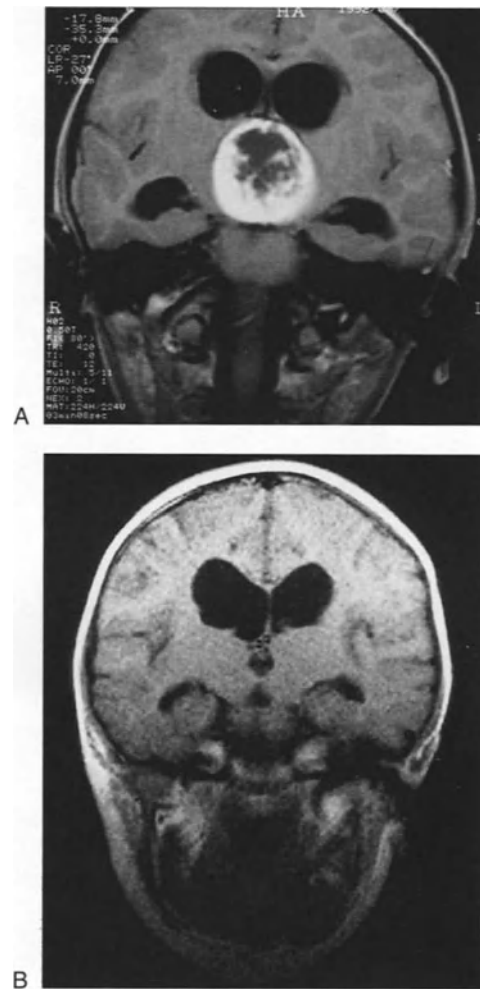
Chiasmatic glioma: (A) This coronal post-gadolinium MRI study reveals the presence of an enormous hypothalamic mass extending from the supra- and retrochiasmatic (floor of the III ventricle structures) areas. The tumor was treated (by Prof. V. Valentino) in three sittings, roughly at 3-month intervals, of radiosurgery. (B) This coronal post-gadolinium study reveals almost complete tumor disappearance.
